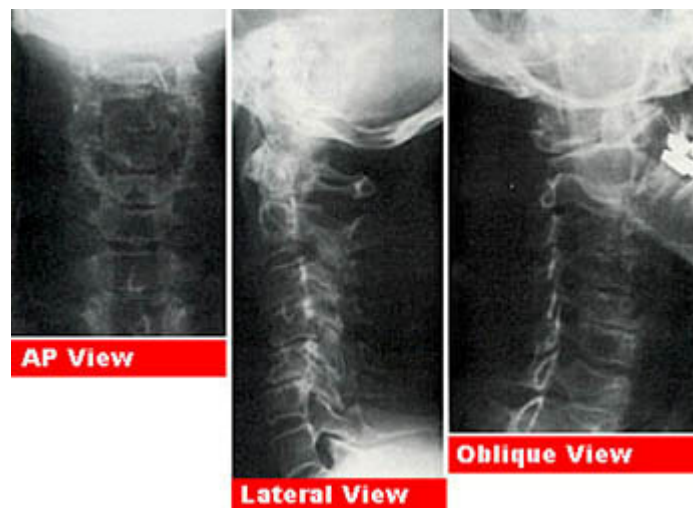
x-ray views of cervical vertebrae
